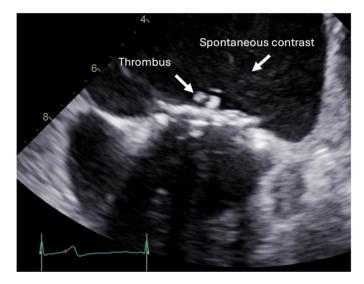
Transesophageal echocardiogram showing intense spontaneous contrast in the left atrium and a small thrombus on the left atrial surface of the occlude device in the interatrial septum.
